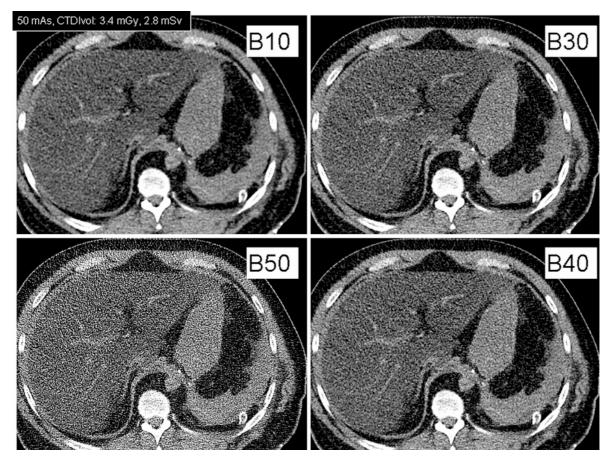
Transverse abdominal CT images reconstructed with various kernels (B10, B30, B40 and B50, Siemens Healthcare). B10 kernel (*smooth*) image shows reduced noise and smoother edges as compared to B50 kernel
